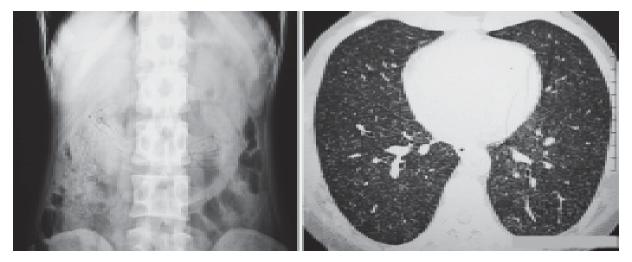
A case of Loeffler's syndrome caused by intestinal round worms. Abdominal X-ray shows the presence of intra-abdominal worms. High-resolution CT of the chest demonstrates ground glass opacities and centrilobular nodules secondary to eosinophilic pneumonia
